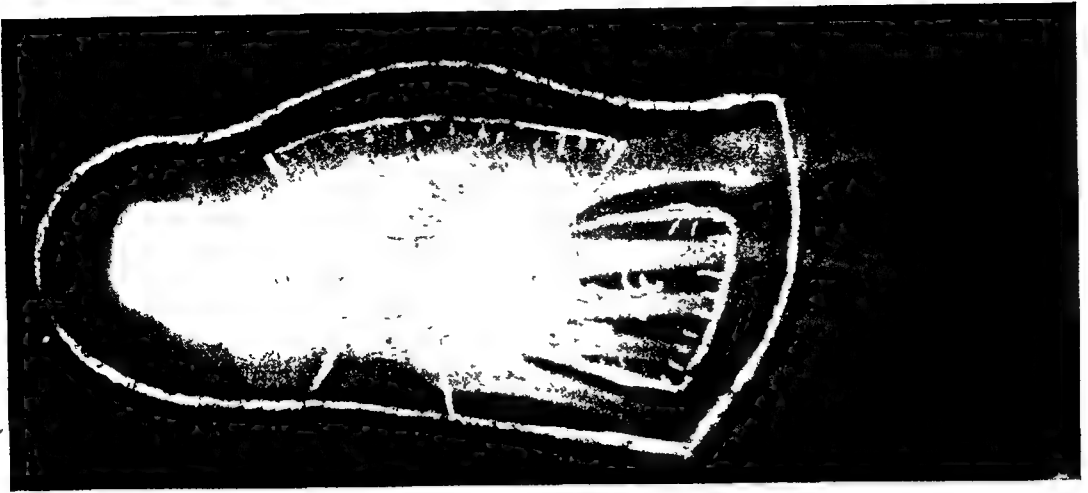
RADIOGRAPH CHART FOR CONVENTIONAL SUPPORTIVE FOOT APPLIANCE.
